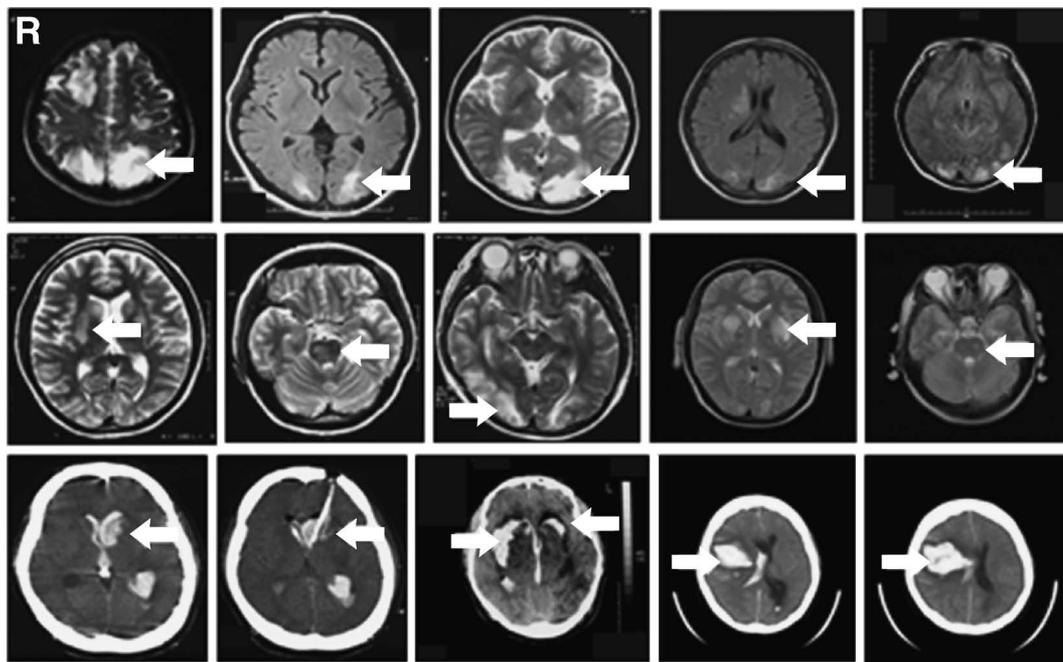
Computed tomography scans and magnetic resonance images of cases of eclampsia (upper and middle rows) and intracerebral hemorrhages (lower row). Arrows indicate localization of brain edema or hemorrhage. *Upper row:* Brain edema located in the white matter of the occipital lobe in eclamptic cases. *Middle row:* Brain edema located in the putamen, thalamus, and pons in eclamptic cases (leftmost image from Case 1). *Lower row:* Intracerebral hemorrhages (leftmost image from Case 2, and rightmost image from Case 3).
